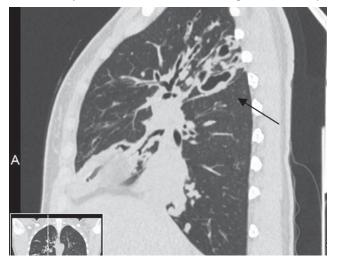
CT pulmonary – bilateral cylindrical and sacciforms bronchiectasis, with thickened walls, pneumosclerosis zones on the left. 18-year-old child, with CF, Ps. aeruginosa chronic pulmonary infection, CFTR genotype 4015delAC/4015delAC
